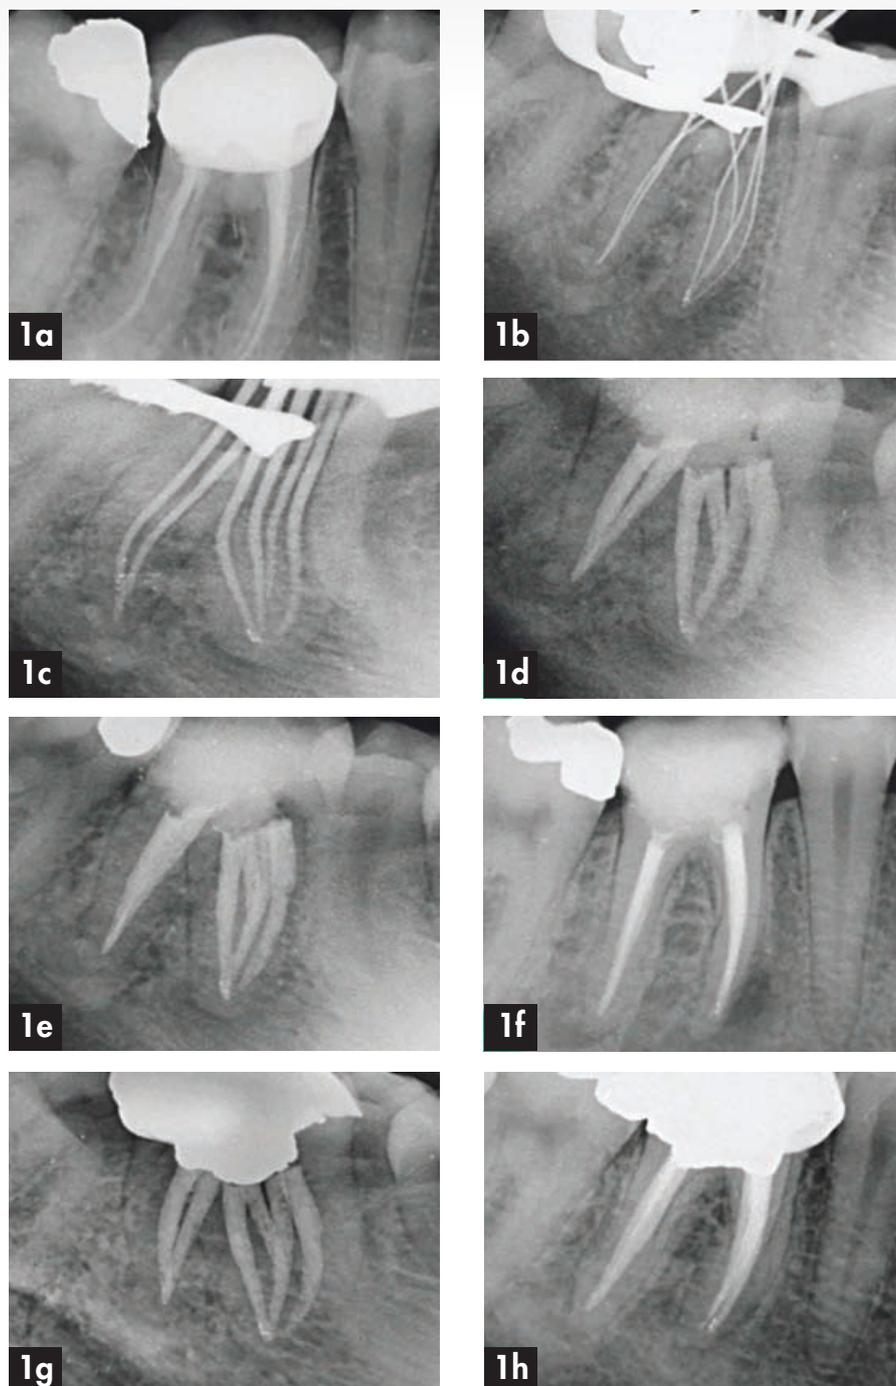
Initial radiograph (a); Radiographic working length confirmation (b); Radiograph of main cones (c); Final radiographs (d-f); Radiographs of 12-month follow-up (g and h).
